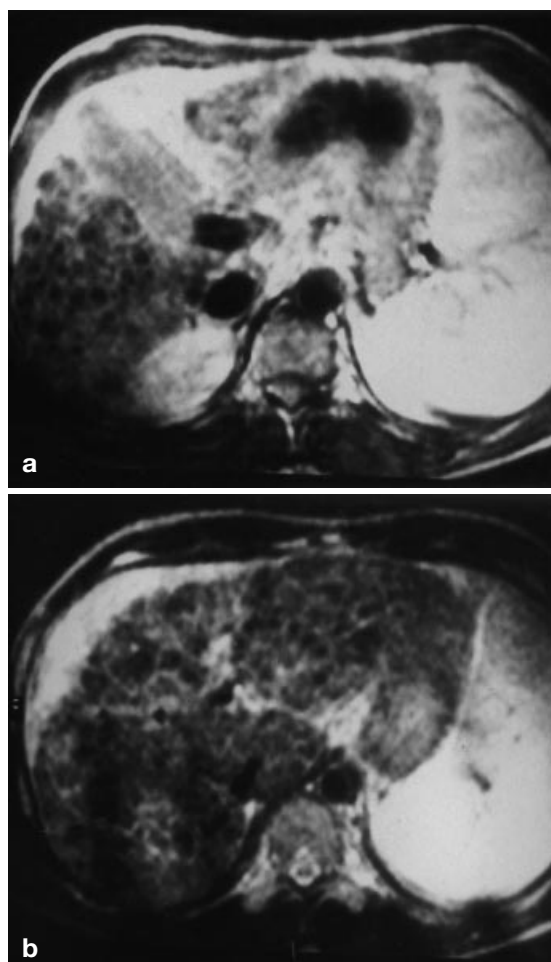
a, b Iron deposits within macroregenerative nodules involving the whole liver parenchyma give a markedly low signal intensity on T2-weighted MR images
